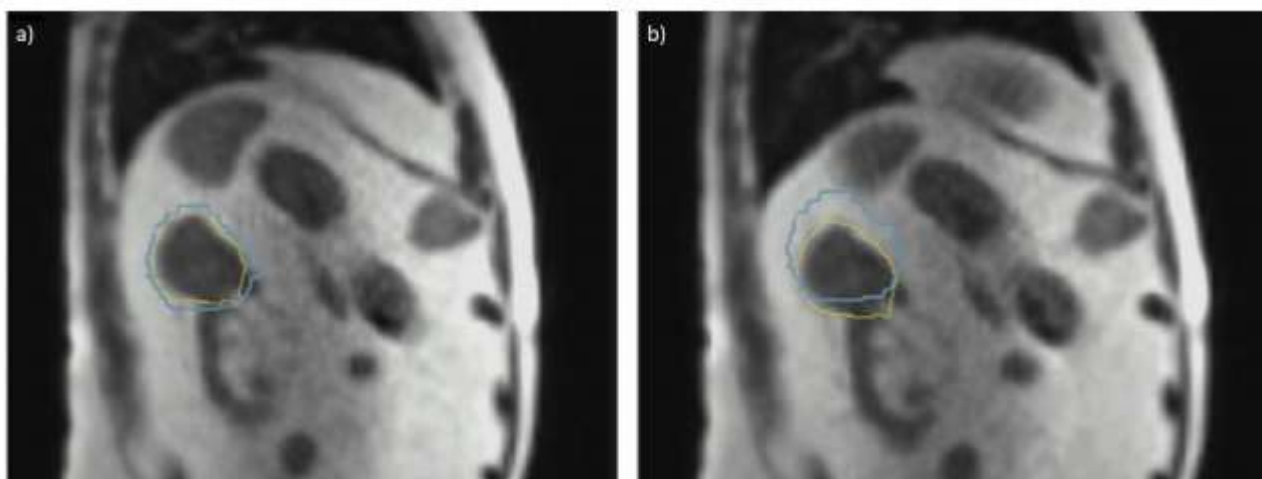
Real-time MRI imaging (0.35T) of a left kidney lesion on an integrated MRI-linac (Viewray, California).
